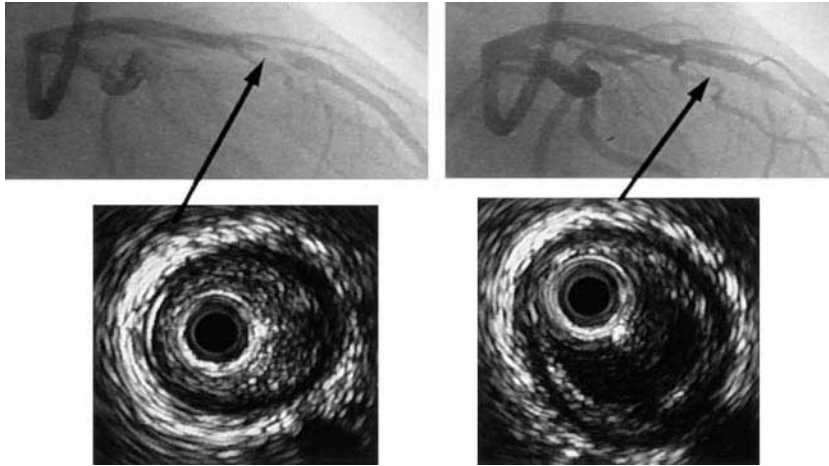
A severe stenosis in the mid LAD was successfully treated with DCA. The ultrasound image shows that before DCA (left) the catheter has been wedged into the plaque. Following atherectomy (right), the lumen is significantly enlarged, but measuring the diameter of the vessel from media to media, the vessel has also been significantly enlarged by stretching, similar to the effect of balloon dilatation.
